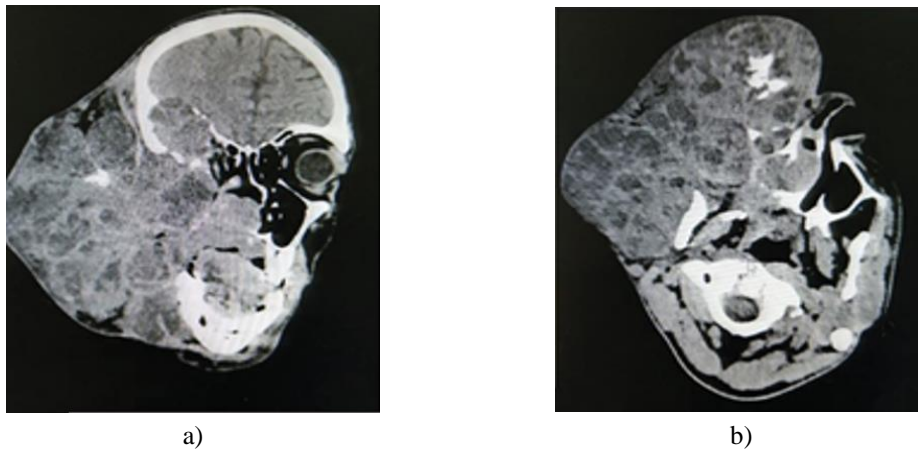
Computed tomography scan appearance of the maxillary lesion;
